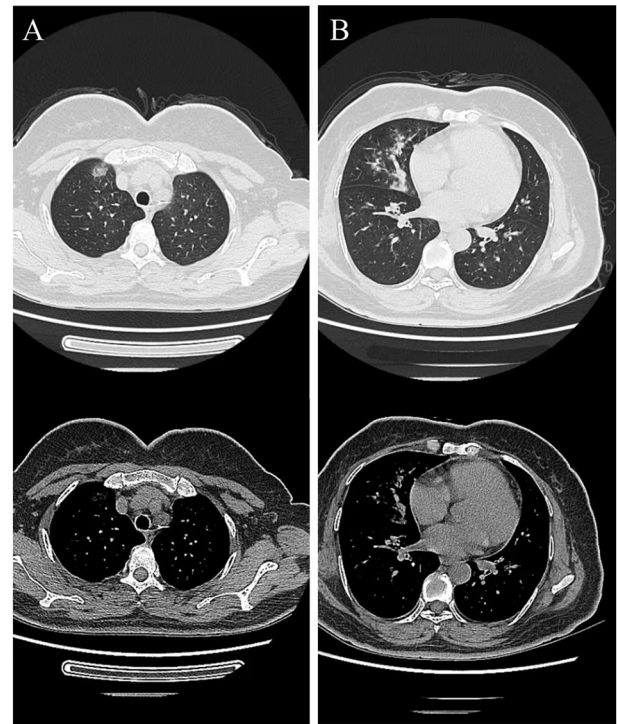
Chest CT imaging of lung lesions upon admission in October 2023. (A) Lung and mediastinal windows of the upper lung lobes. (B) Lung and mediastinal windows of the lower lung lobes. Patchy and nodular opacities with slightly increased attenuation and ill-defined margins are visible.
